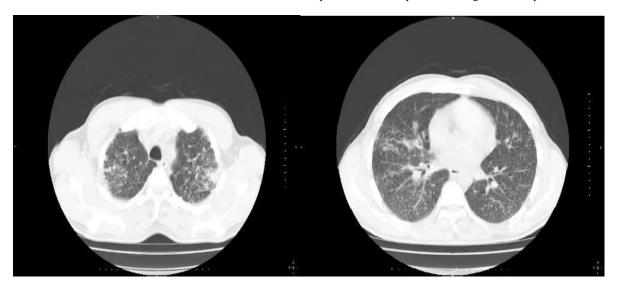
Thorax computed tomography slides of the patients
